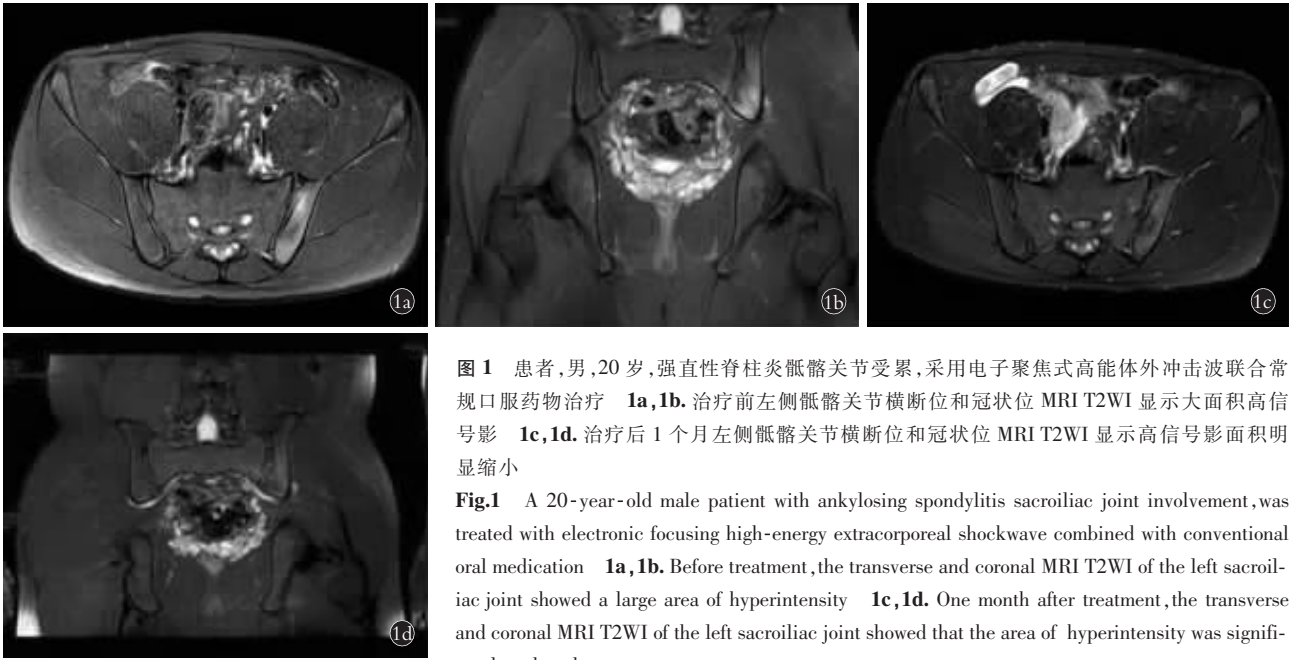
患者,男,20 岁,强直性脊柱炎骶髂关节受累,采用电子聚焦式高能体外冲击波联合常规口服药物治疗 1a,1b. 治疗前左侧骶髂关节横断位和冠状位 MRI T2WI 显示大面积高信号影 1c,1d. 治疗后 1 个月左侧骶髂关节横断位和冠状位 MRI T2WI 显示高信号影面积明显缩小
